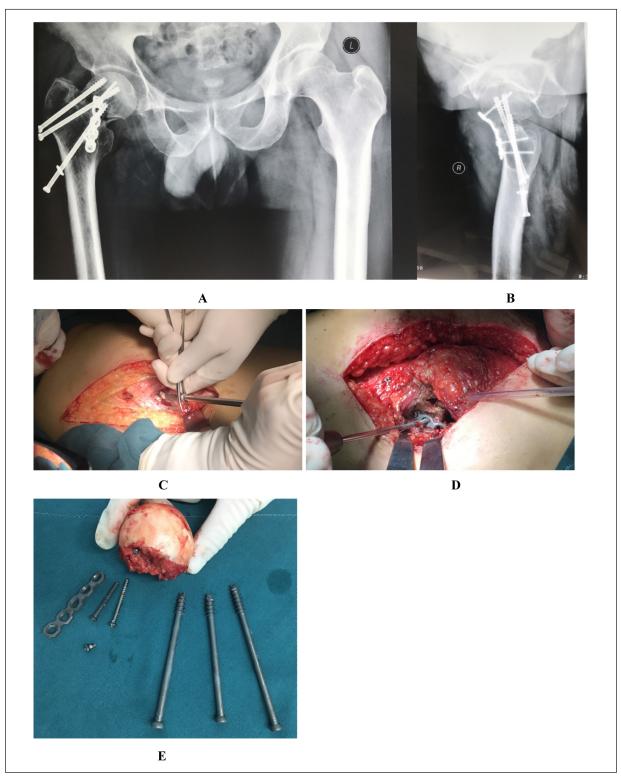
Radiographs of a 50-year-old man showing medial buttress plate combined with hollow screws for femoral neck fracture with nonunion and hollow screws retraction (A-B). The modified Hardinge approach removes hollow screws at the greater trochanter (C). After flexion and external rotation, the medial buttress plate (D) is removed through the front. Femoral head and internal fixation after removal (E). Axial radiographs of the lower pelvis and hip joint showing salvage THA for failed internal fixation (F-G). Prosthesis position at last follow-up (H-I).
